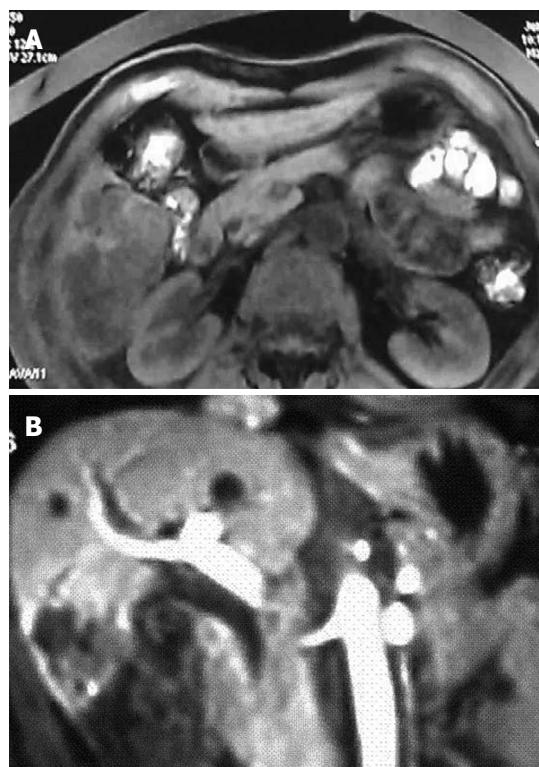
Magnetic resonance imaging. A: A hypodense nodule and hepatocellular carcinoma before therapy; B: A hypodense nodule with partial contrast enhancement before hepatectomy.
